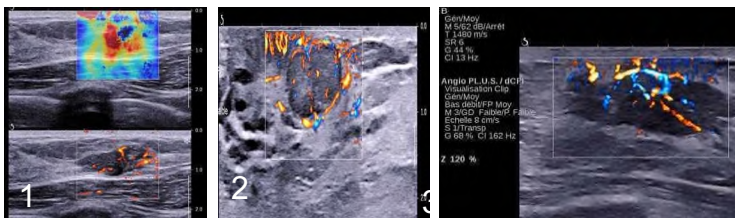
& 2 malignant lesion: elastography & Doppler.
